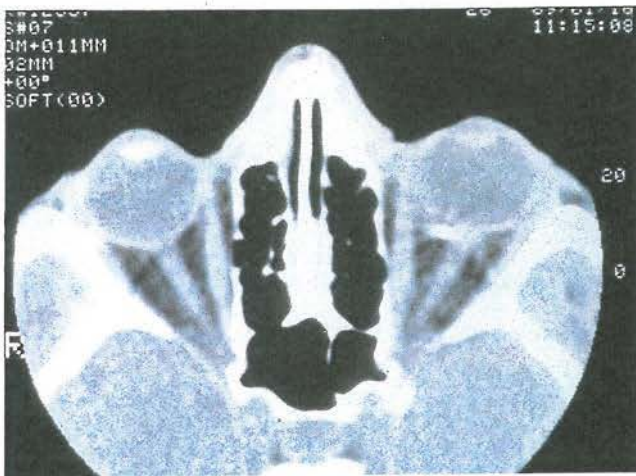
Axial CT scan showing a foreign body near the left optic nerve
